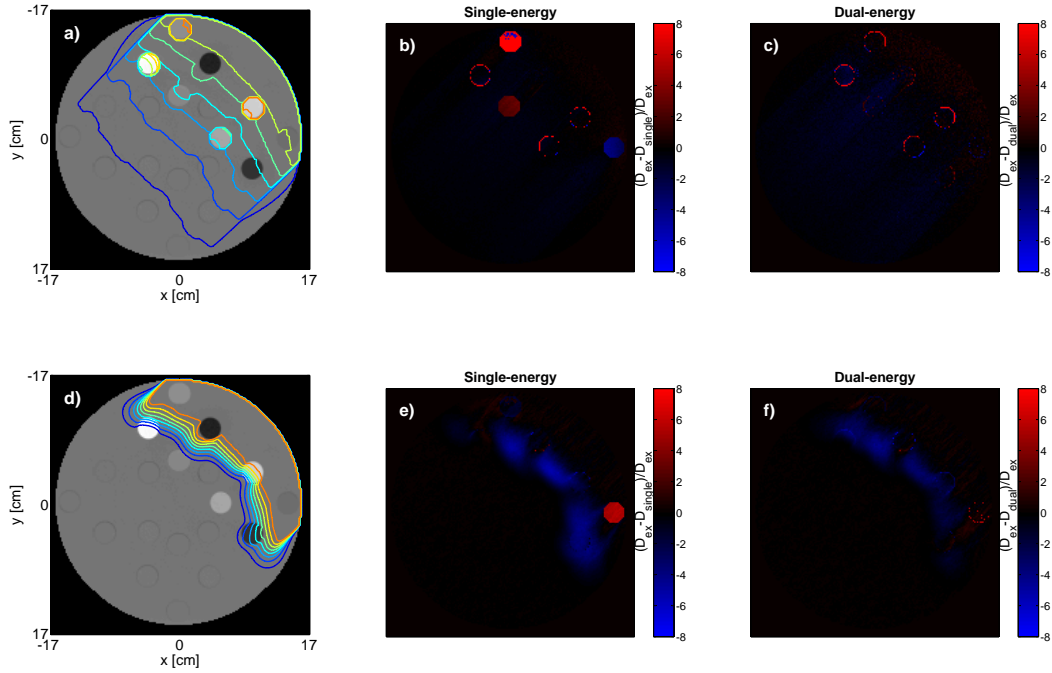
Dose distributions in the exact geometry for a single 250 kVp photon beam (a) and for a single 18 MeV electron beam (d). The dose calculation errors in the single-energy CT geometry (b,e) and the dual-energy CT geometry (c,f) for a single 250 kVp photon beam and a single 18 MeV electron beam, respectively. Dose differences are defined as $(D_{\text{ex}} - D_{\text{single or dual}})/D_{\text{ex}}$.
